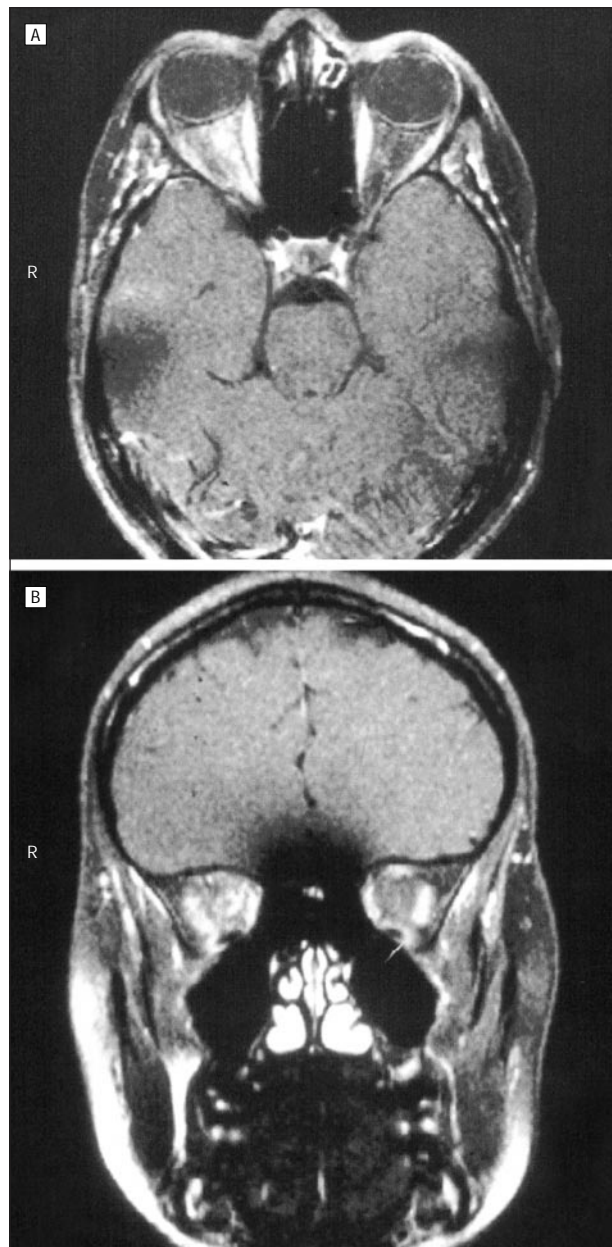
Patient 1. Magnetic resonance imaging scan of the head and orbits, with contrast infusion and fat suppression. A, The axial view shows enhancement around the right intraorbital optic nerve with some “streakiness” of the surrounding orbital fat. R indicates right side. B, The coronal view confirms that the enhancement is around, rather than within, the optic nerve.
